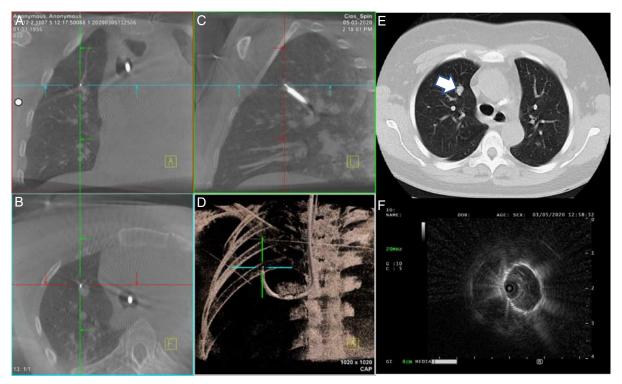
Bronchoscopy with the ultrathin scope, radial endobronchial ultrasound (r-EBUS) and 2D/3D fluoroscopy of a 12 mm right upper lobe (RUL) lung nodule. A, Coronal plane view showing r-EBUS probe inside the nodule and cross section of bronchoscope in trachea. B, Axial plane view showing r-EBUS probe inside the nodule and cross section of bronchoscope in trachea. C, Sagittal plane view showing r-EBUS probe inside the nodule and the distal end of bronchoscope touching the nodule. D, 3D configuration with bone enhancing view showing the entire bronchoscope in lung. E, A representative axial plane cut of the CT scan showing the RUL anterior segment nodule (white arrow). F, Concentric r-EBUS view of the lung nodule.
